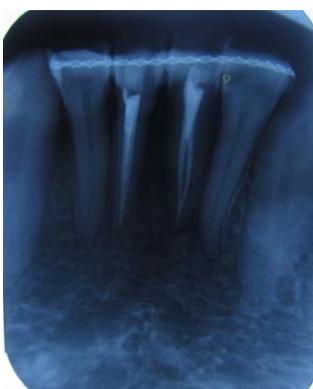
postoperative radiographs showing type II canal configuration in both 31 & 41.
